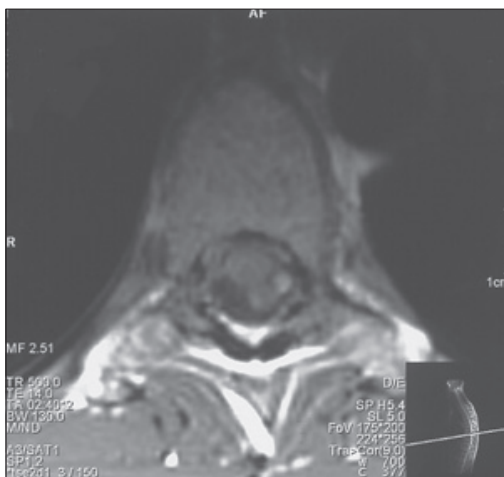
MRI of the thoracic spine with contrast agent applied, transversal cross-section through the Th 5–Th 6 intervertebral space, post-contrast – posterior intramedullary process with peripheral opacity of the left side of the medula spinalis.
